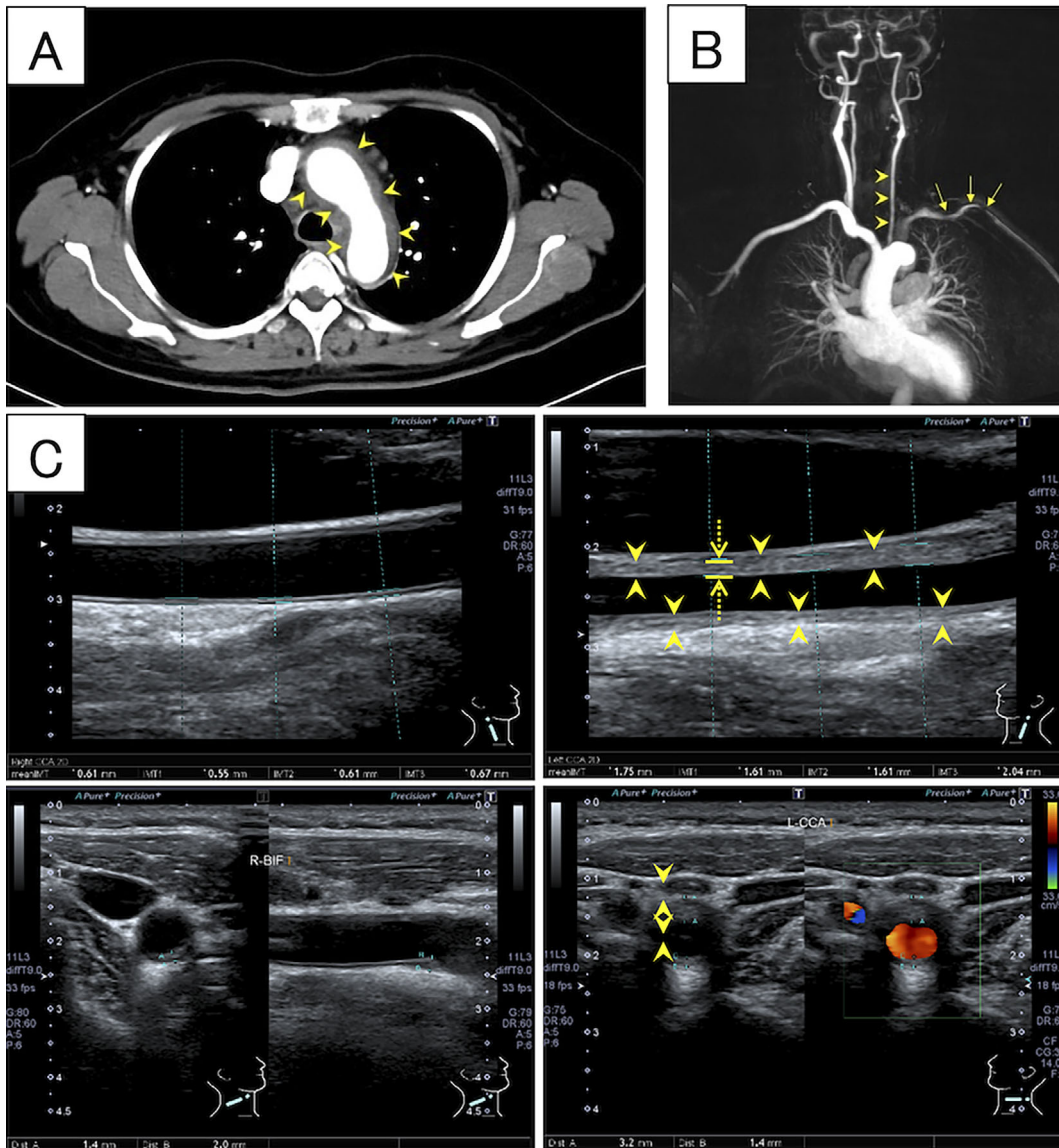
Image findings of arteritis. A) Contrast-enhanced computed tomography (CT) of the aortic arch. CT showing thickened walls of the aortic arch (arrowheads). B) Contrast-enhanced magnetic resonance angiography (MRA) of the neck and chest. MRA showing a narrowing of the left carotid artery (arrowheads) and left subclavian artery (arrows) plus non-visualization of the left vertebral artery. C) Ultrasonography of the common carotid artery. Left upper panel) Right, longitudinal section. Right upper panel) Left, longitudinal section. “Macaroni Sign” visible as long, homogeneous, isoechoic wall thickening (arrowheads). Dotted arrows indicate the intima-media thickness (IMT). Left lower panel) Right, transversal section. Right lower panel) Left, transversal section. Circumferential wall thickening (arrowheads).
